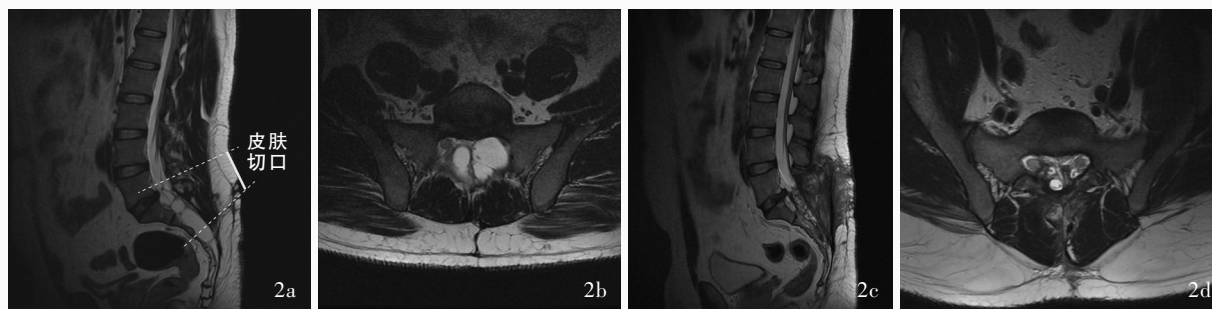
女性患者, 51 岁, 临床诊断为症状性骶管 Tarlov 囊肿, 行显微改良瘘口封堵术。手术前后腰椎椎 MRI 检查所见 2a, 2b 术前矢状位和横断面 T₂WI 显示, S₁₋₃ 多发椎管内 Tarlov 囊肿 2c, 2d 术后近 4 年矢状位和横断面 T₂WI 显示 Tarlov 囊肿完全消失
